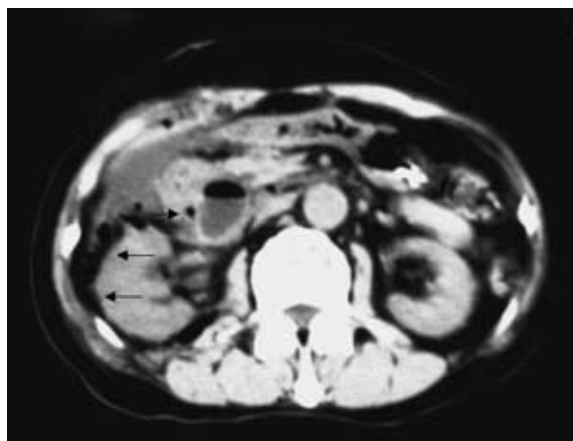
Computed tomography of the abdomen shows retroperitoneal air around the duodenum, right kidney, and ascending colon (←).
